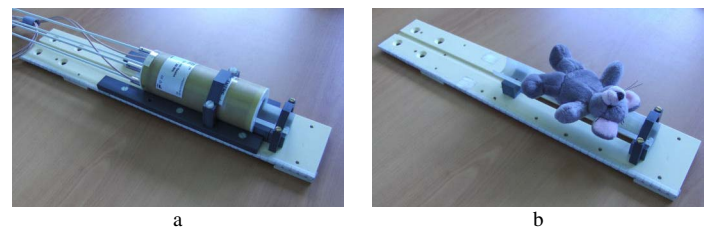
Photographs of the dedicated bed in MRI (a) and PET (b) configuration.
